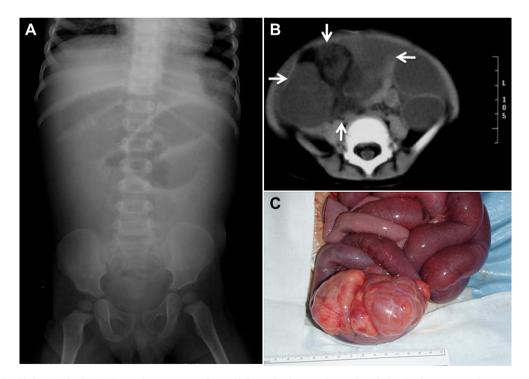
(A) Abdominal plain X-ray demonstrated small bowel obstruction. (B) Abdominal computed tomography revealed dilated small bowel and a heterogeneous mass without calcification. (C) Intraoperative photograph shows a soft and lobulated tumor with smooth, glistening capsule arising from the mesentery 180 cm distal to the Treitz' ligament. It shows that the small intestine has rotated 360° around the tumor, and an additional 360° rotated small intestinal volvulus around the more proximal mesentery was also found.
